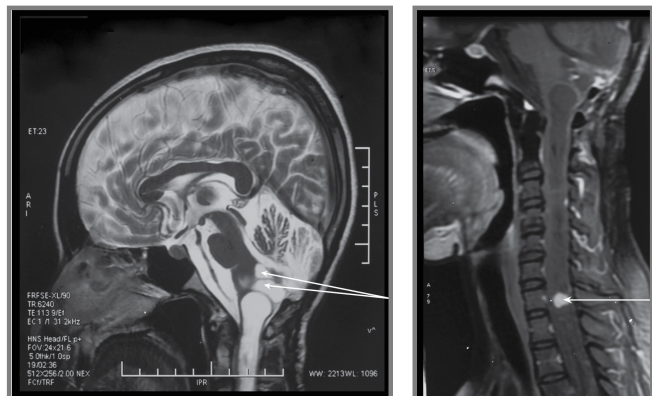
(a) T2 weighted sagittal MRI brain of the female proband showing the recurrent cerebellar haemangioblastoma and (b) T1 weighted post contrast sagittal MRI of the cervical spine showing spinal haemangioblastoma.
